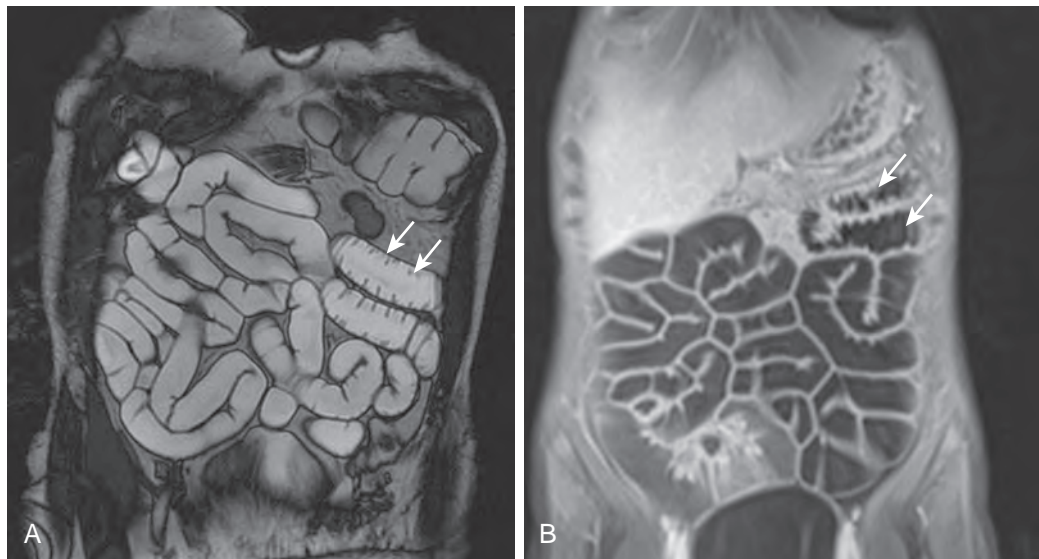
Normal MR enterography findings. Iso-osmotic polyethylene glycol–water solution (biphasic contrast agent) acts as a positive intraluminal contrast agent (bright lumen) on (A) true FISP as a negative agent (black lumen) on a 3D T1-weighted fat-saturated VIBE image (B). Normal valvulae conniventes (arrows) in a well-distended jejunum are visible.
